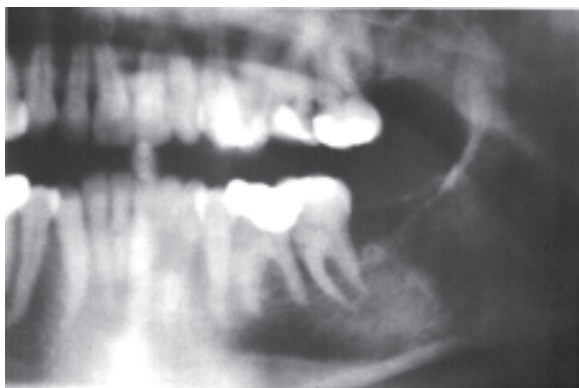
Radiograph showing a large mixed radiolucent and radiopaque area in the posterior mandible (metastatic adenocarcinoma from breast)
